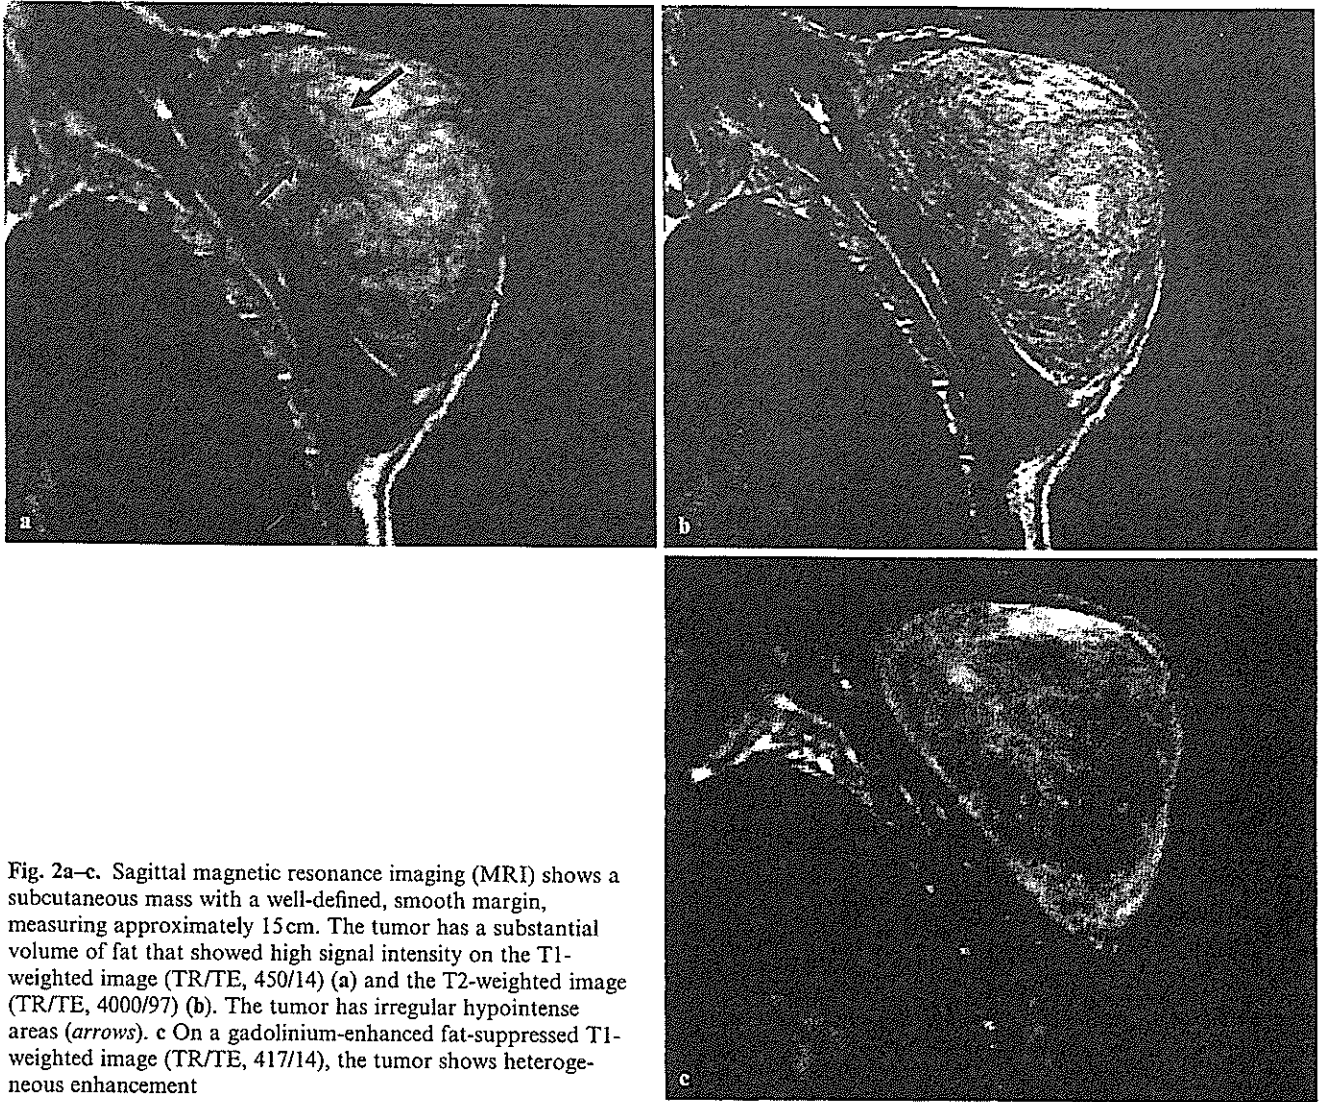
Sagittal magnetic resonance imaging (MRI) shows a subcutaneous mass with a well-defined, smooth margin, measuring approximately 15 cm. The tumor has a substantial volume of fat that showed high signal intensity on the T1-weighted image (TR/TE, 450/14) (a) and the T2-weighted image (TR/TE, 4000/97) (b). The tumor has irregular hypointense areas (arrows). c On a gadolinium-enhanced fat-suppressed T1-weighted image (TR/TE, 417/14), the tumor shows heterogeneous enhancement
